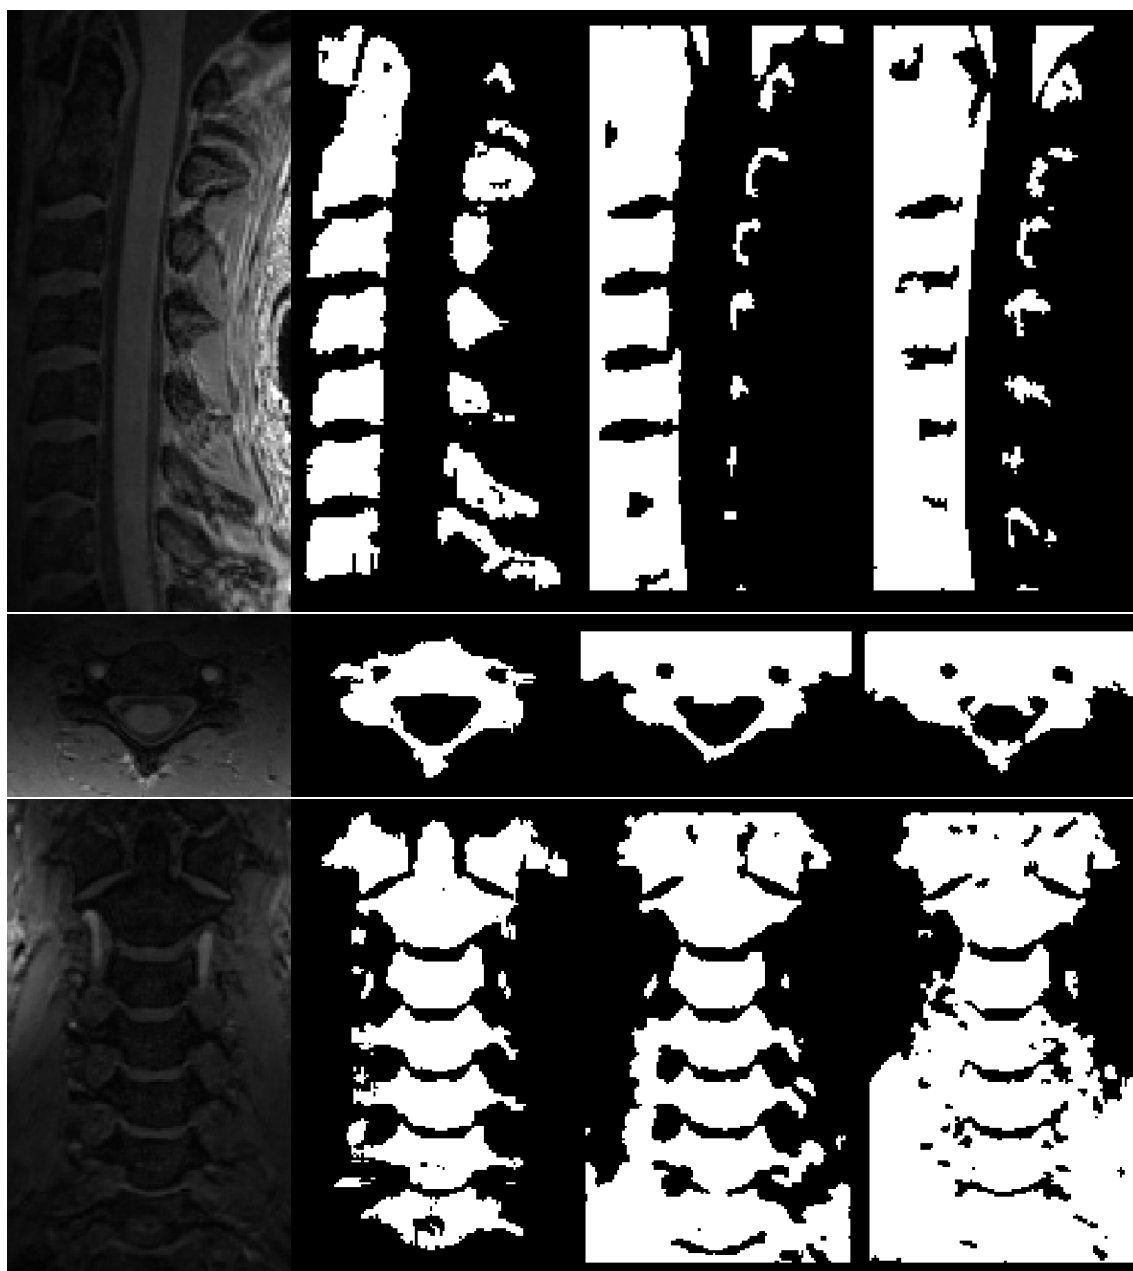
Comparison of the segmentations from the fifth subject. From left to right: a) MRI, b) manual segmentation, c) semi-automatic segmentation, and d) automatic segmentation. Top to bottom, the sagittal plane, the transverse plane and the coronal plane.
